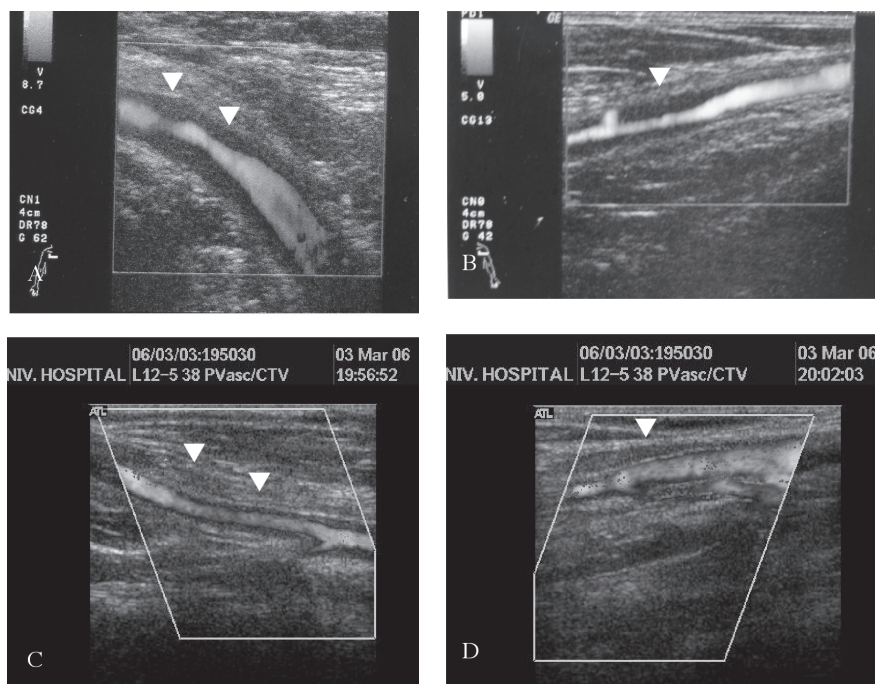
Doppler ultrasound studies showed right axillary artery stenosis (A) and left axillary artery stenosis (B). After a year of treatment a significant degree of improvement were noted of both axillary arteries (C and D respectively).
